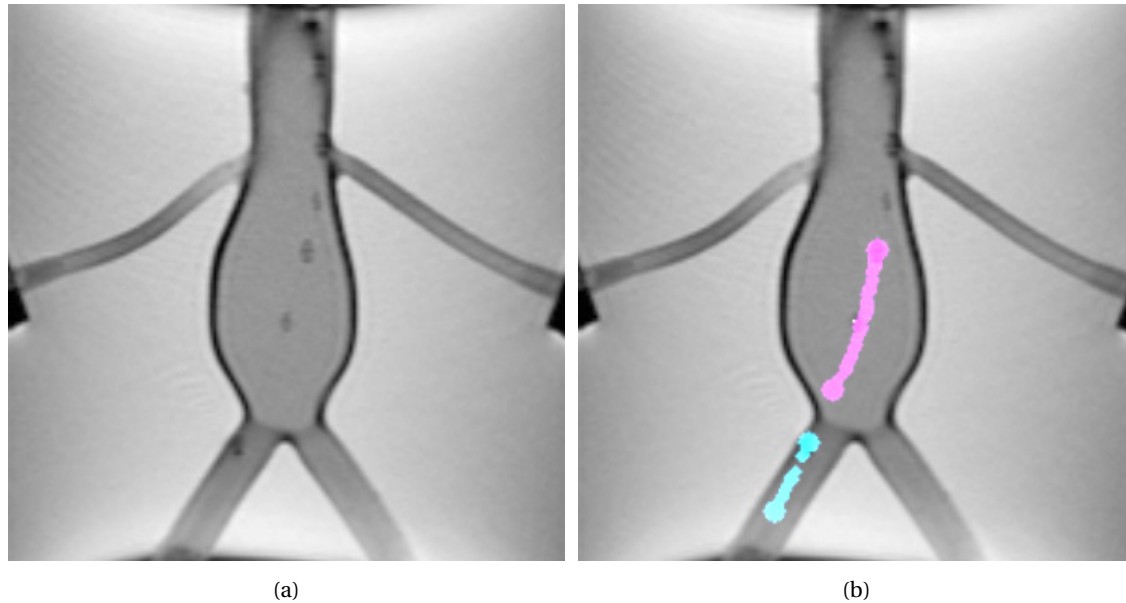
(a) Original MR image (b) Tracked artefacts, larger circles represent the start and end position, while smaller dots show the movement trajectory over multiple frames.
